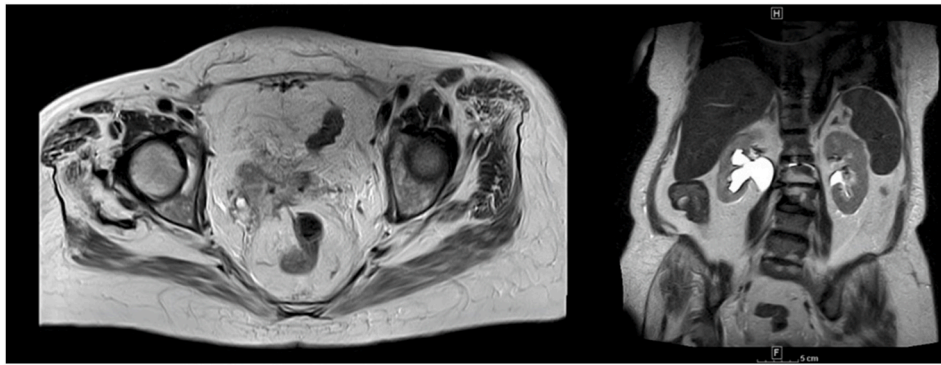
MRI depicting right hydronephrosis associated with right vaginal cuff fluid collection.
